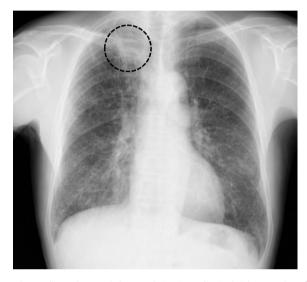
Chest radiography revealed a mass lesion in mediastinal right upper lung field. Tumor lesion was indicated by dotted circle.
